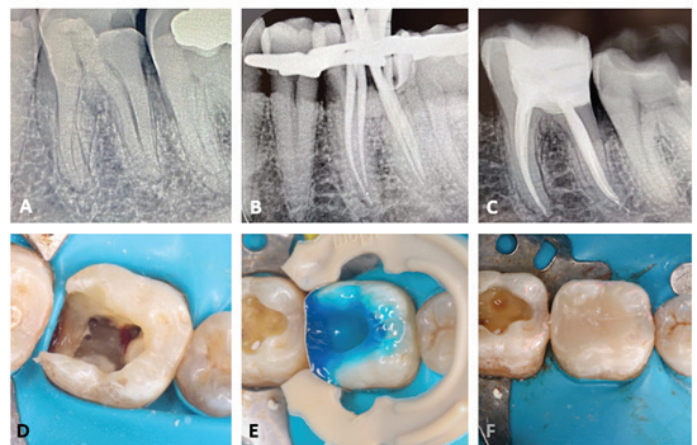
Endodontic Treatment of #36 (A): A periapical X-ray confirmed deep caries, seen as a radiolucency on the distal side of tooth (B): Master cone try-in (C): After obturation and buildup (D): Access cavity (E): Total-etch technique (F): Postoperative
